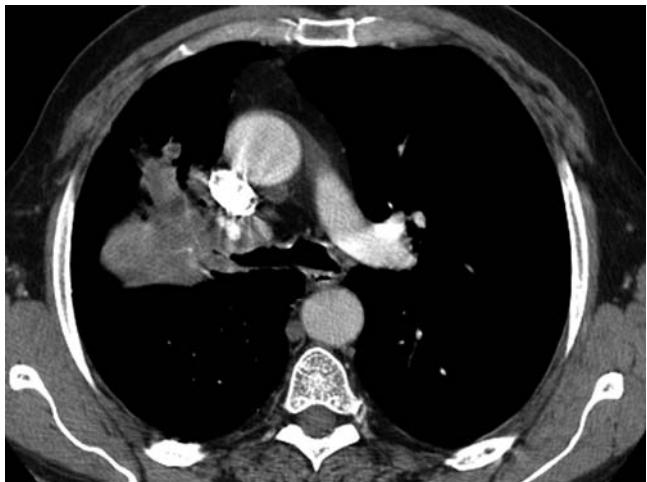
CT of chest showing large irregularly shaped mass lesion in the hilar area of the right upper lobe. Biopsy showed a metastatic salivary gland tumor.
